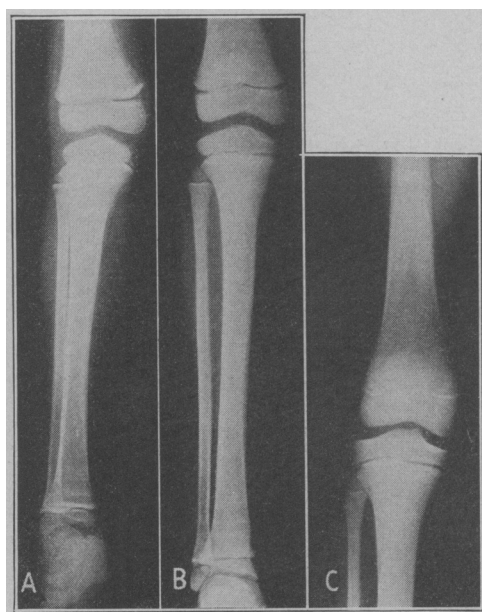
(case 11).—*A*, at 5 years of age, showing dense bands at the growing ends of the shafts of the long bones; *B*, at 7 years, showing nearly complete disappearance of the roentgen evidence of lead in the long bones; *C*, at 11 years, showing no roentgen evidence of lead in the long bones. At the time roentgenogram *C* was made, the patient's blood showed anemia and stippled cells and she seemed to have a mild encephalopathy.
